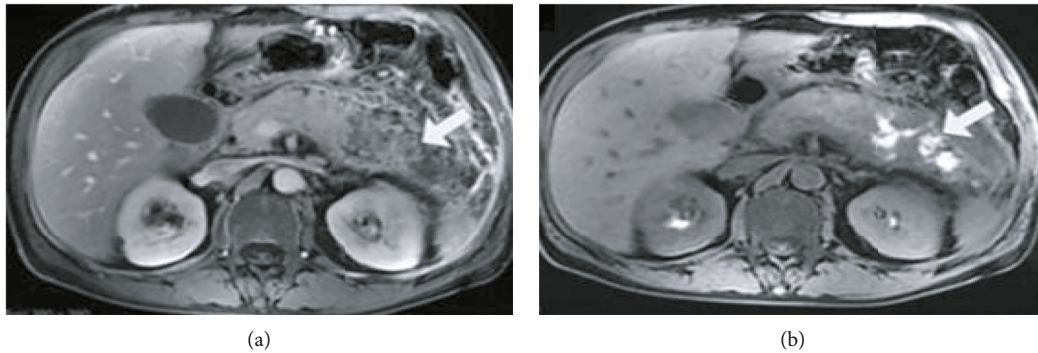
Denoised MRI image of a postoperative pancreatitis patient. Note: the figure shows denoised MRI images of patients with postoperative pancreatitis, in which the arrow in (a) shows large nonenhanced manifestations of pancreas and surrounding area, and the arrow in (b) shows T1WI image, with high shadow at the site indicated by the arrow, indicating the possibility of bleeding.
